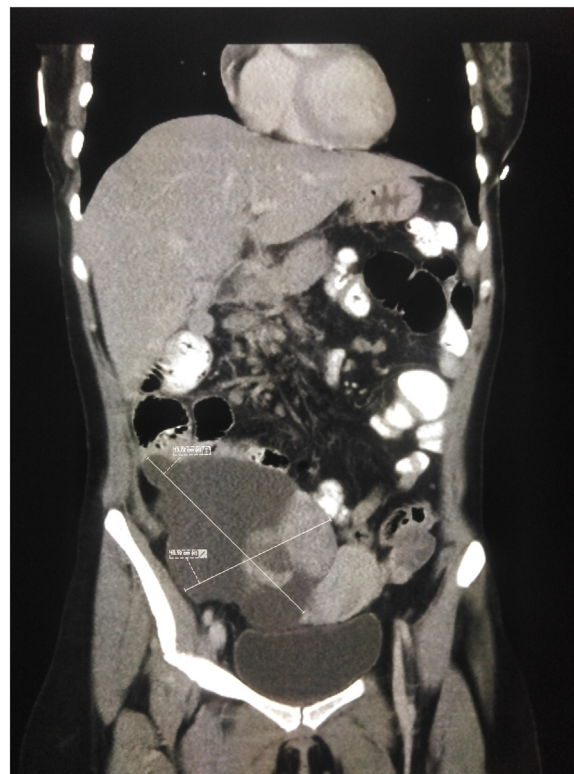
Contrast enhanced CT scan abdomen & pelvis (Coronal view). Bilateral ovarian masses with cystic and solid component, large Right ovarian mass measures 13 × 10 cm.
